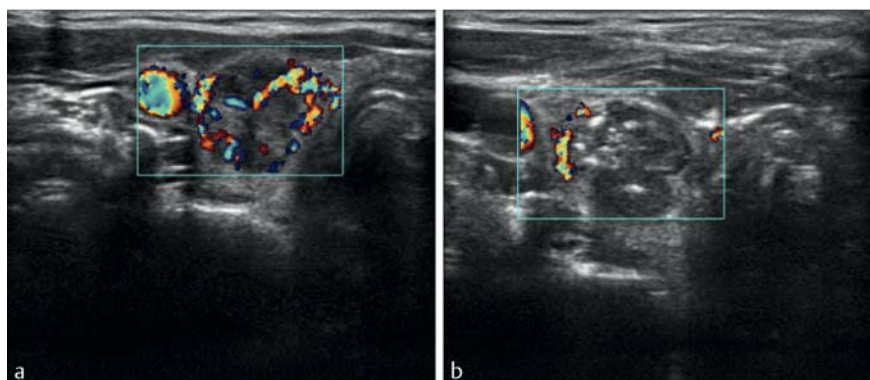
Decrease of Doppler blood flow after bipolar radiofrequency ablation (RFA) as proof of efficacy. (Ratings: marked intra-/perinodal perfusion before a and slight intra-/perinodal perfusion after therapy b).
